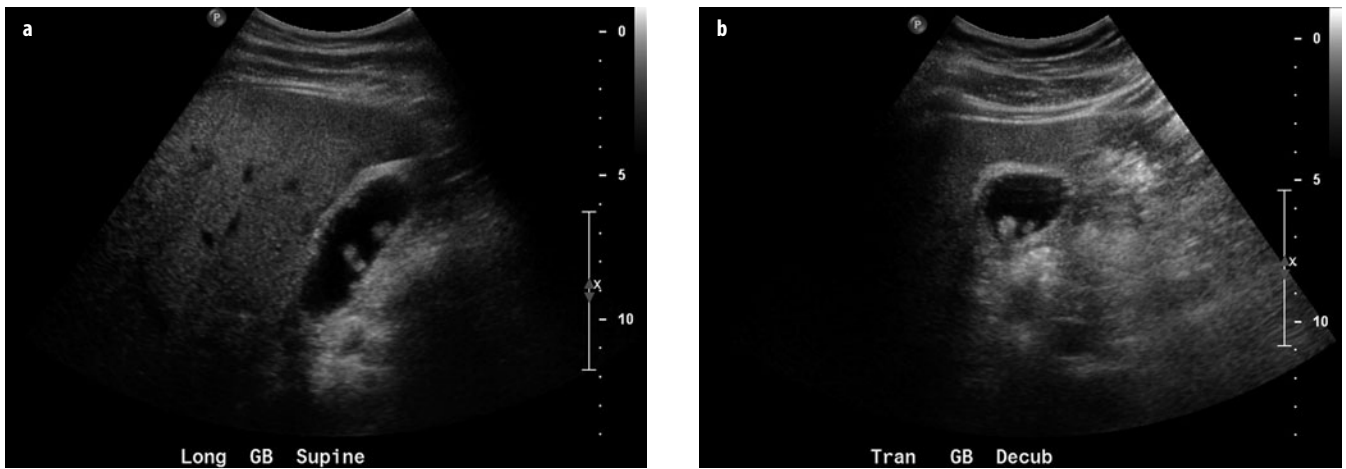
a, b. Cholesterol polyps. Longitudinal (a) and transverse (b) ultrasound (US) images show multiple small, hyperechoic, intraluminal gallbladder polyps
